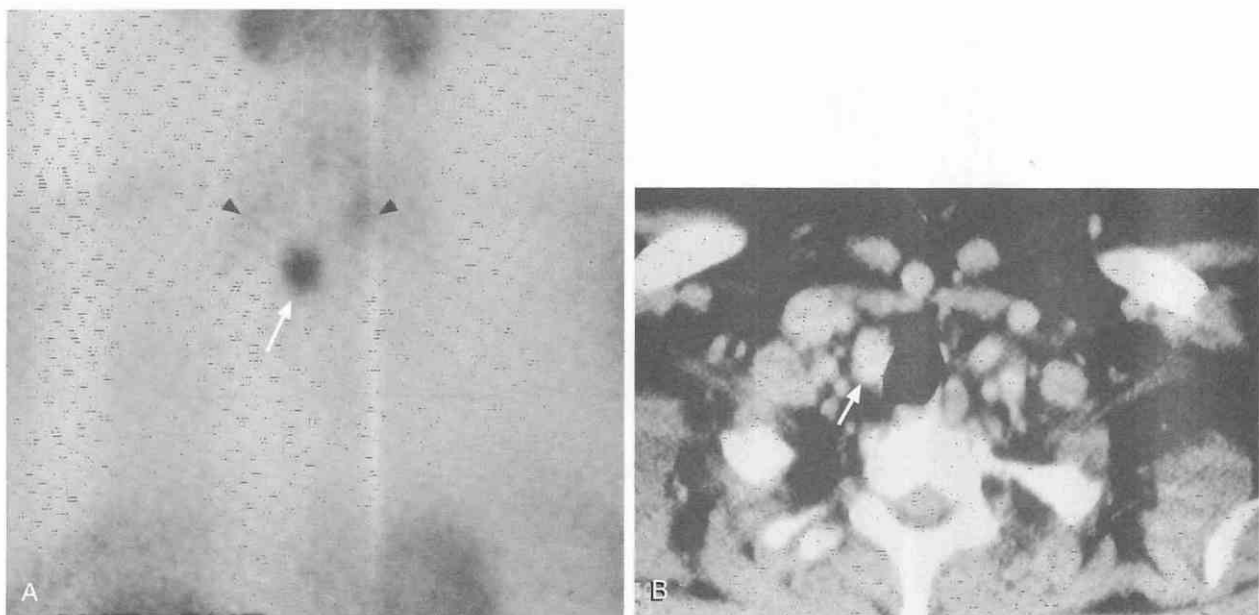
A, Anterior projection of neck and upper chest from a technetium 99m-MIBI radionuclide scan in a patient with persistent hyperparathyroidism after thyroidectomy demonstrates a prominent focus of tracer uptake within the low right neck (arrow). Uptake within the thyroid parenchyma (arrowheads) is mild. B, Axial postcontrast CT scan through the lower neck in the same patient demonstrates an enhancing right paratracheal soft tissue mass (arrow), found to be a parathyroid adenoma at reoperation.
